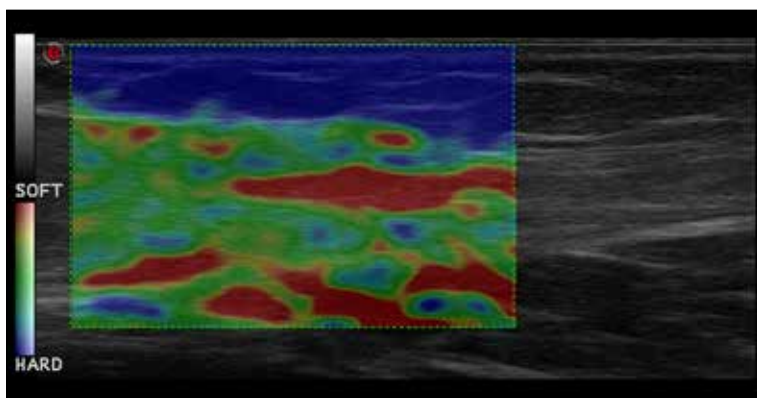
Follow-up ultrasound examination 7 days after the initial test. US elastogram presents a mosaic of colors.
